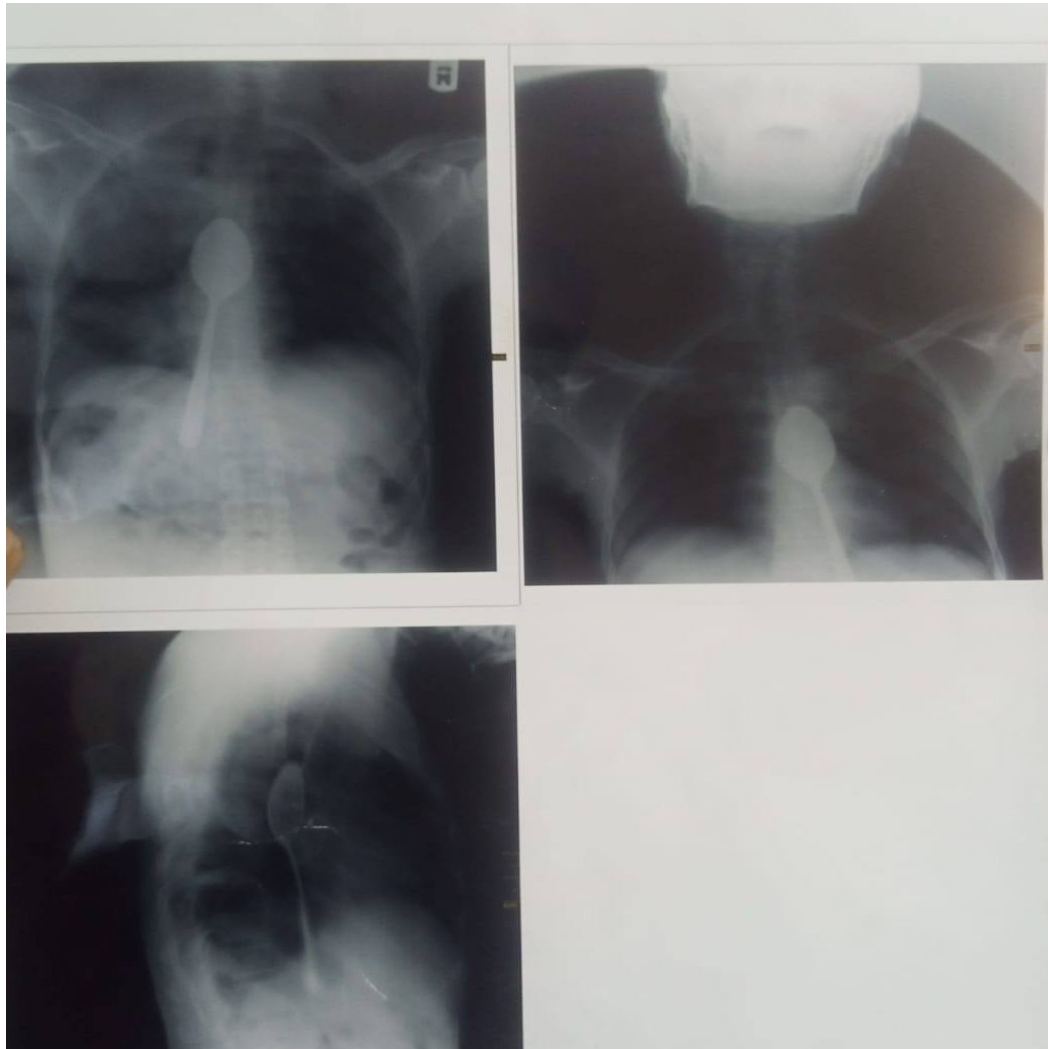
PA and lateral Chest X-Ray images showing a spoon-shaped radio-opaque object in the retrosternal area of a 48-year old male, following accidental ingestion of a table-spoon
